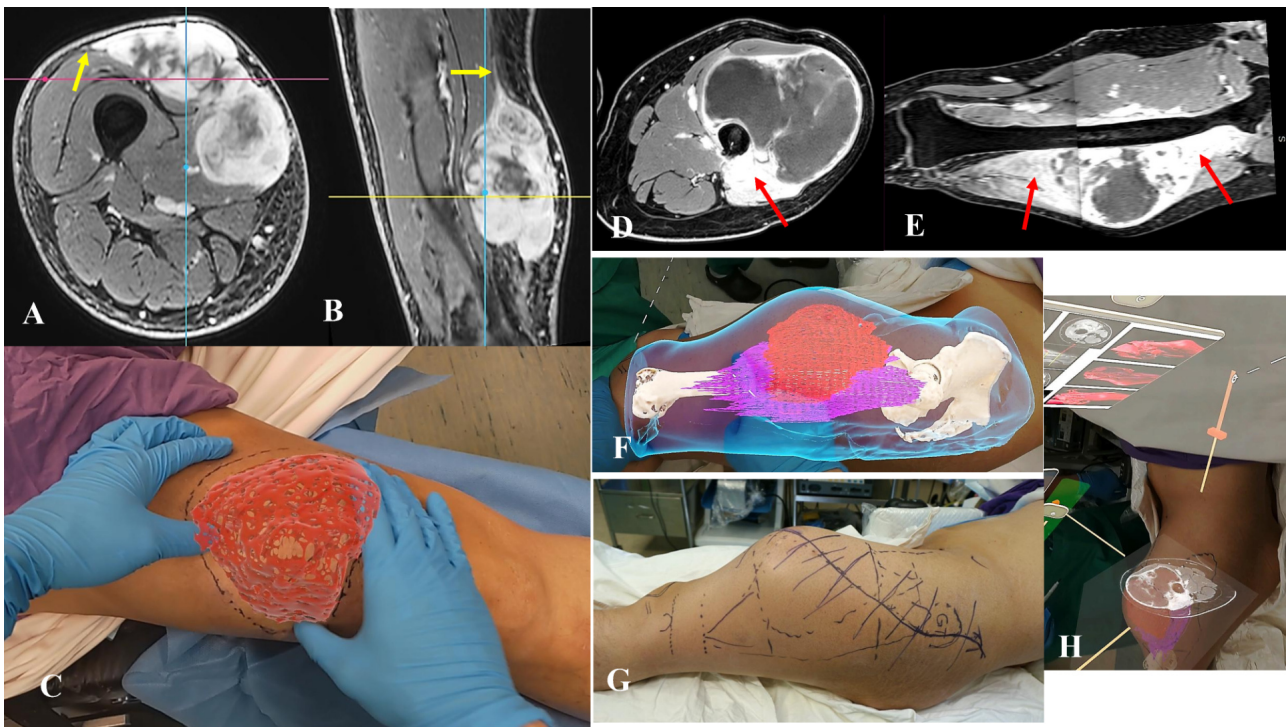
Tumor information, including nonpalpable fascial tumor extension (A–C, yellow arrow), peritumoral edema (D–G, red arrow), and 2D axial contrast-enhanced MRI images (H), was evaluated in the patient with thigh high-grade soft-tissue sarcoma.
